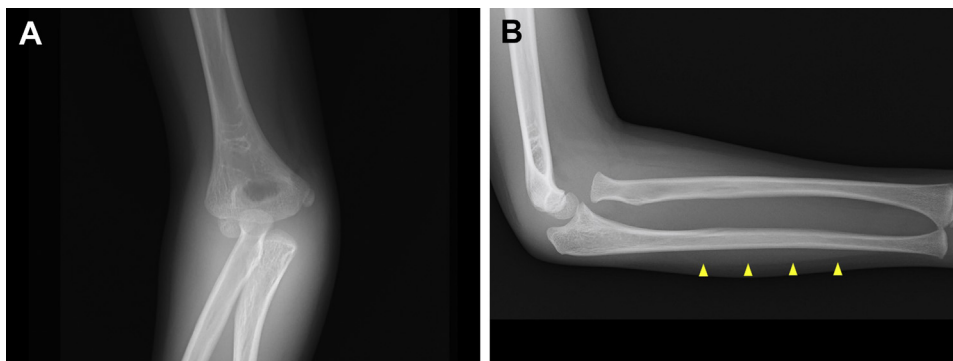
(A) Anteroposterior and (B) lateral radiographs of the *Right* elbow at the time of injury. The radial head is dislocated anteromedially with minimal plastic deformation of the ulna (arrow heads).
